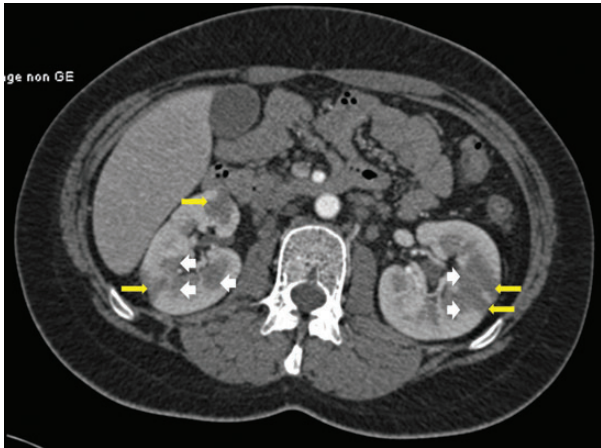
Transverse contrast-enhanced abdominal CT during corticomedullary acquisition time displaying multiple, low-attenuation wedge-shaped foci seated in the cortex of both kidneys (yellow arrows) and low-attenuation corticomedullary nodules (white arrowheads) also present in both kidneys.
